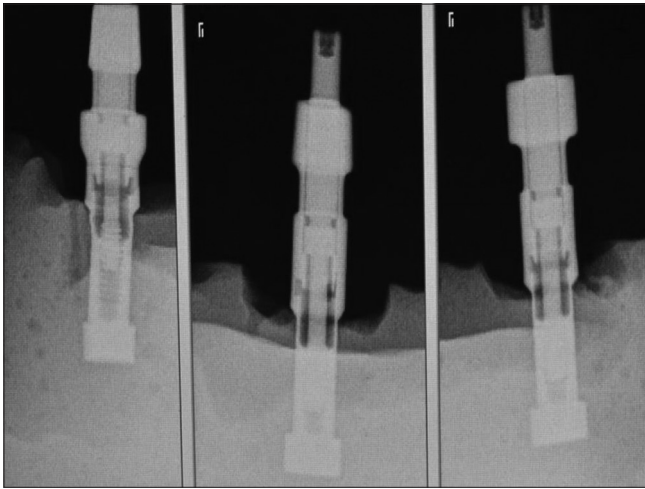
IOPA of the modified implant open tray impression after pouring the cast. IOPA: Intra Oral Periapical radiographs
